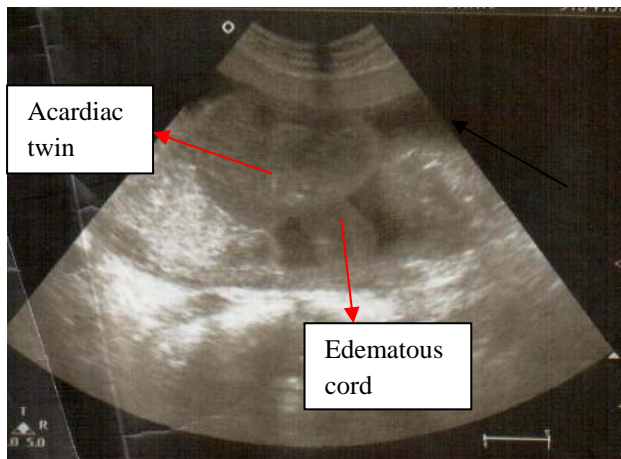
Ultrasound Image Showing Edematous Cord of Twin A and the Amorphous Acardius Twin B
